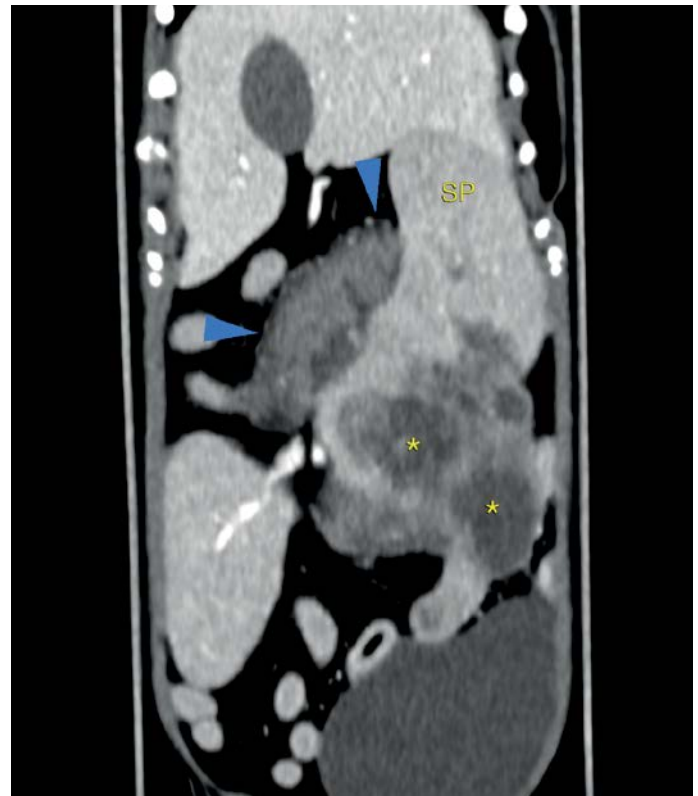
A dorsal plane reconstruction of an abdominal CT examination post contrast showing a large heterogenous splenic mass with subcapsular hemorrhage (arrow heads).
